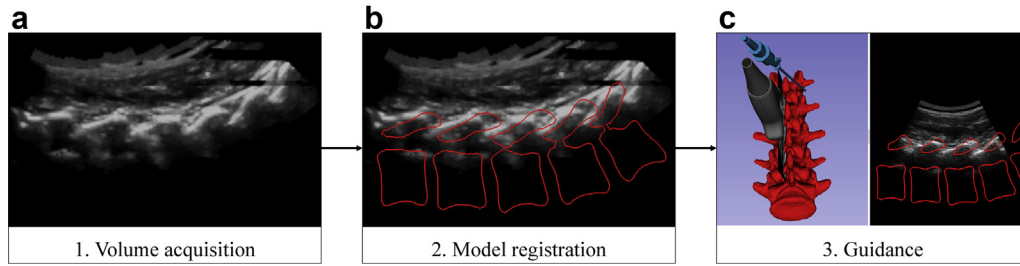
Workflow of ultrasound-guided spine anesthesia. (a) An ultrasound volume is acquired from tracked 2-D ultrasound slices. (b) The statistical 3-D surface model of the lumbar spine (red) is optimized and registered to the reconstructed volume. (c) The registered statistical model of the spine is used to highlight anatomical features (in this case, the surface of the vertebrae on the right side) in the live 2-D ultrasound image and is visualized along with the tracked injection needle in the 3-D guidance interface (left side).
